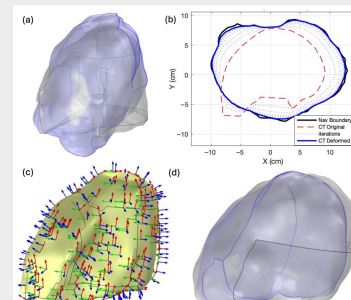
Registration for a representative patient: (a) initial navigation/CT overlay; (b) iterative boundary convergence (X-Y plane); (c) Stage-2 von Mises stress & displacement field; (d) final registered overlay.
